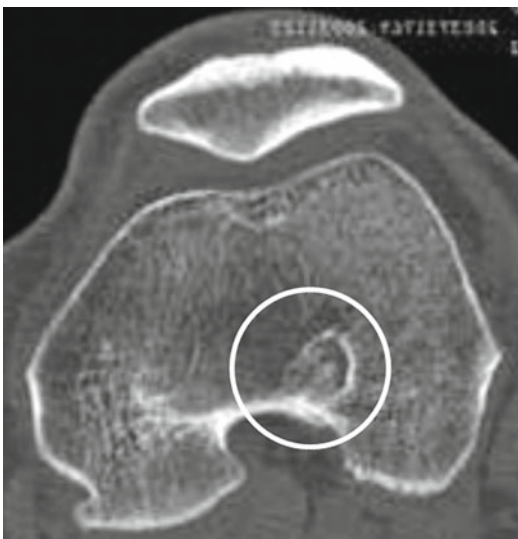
CT scan 4 months following bone grafting. circle is making the bone grafted tunnel
